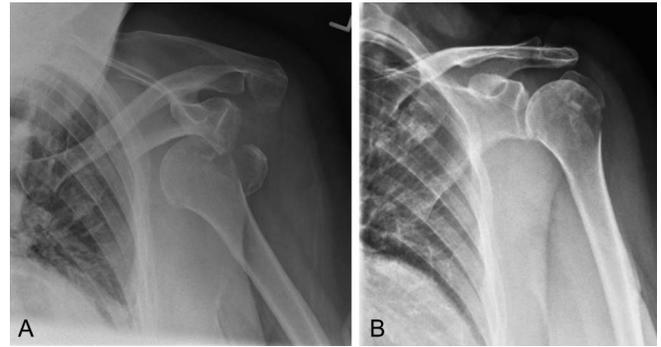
A and B, Prereduction and postreduction radiographs demonstrating a displaced greater tuberosity fracture.
